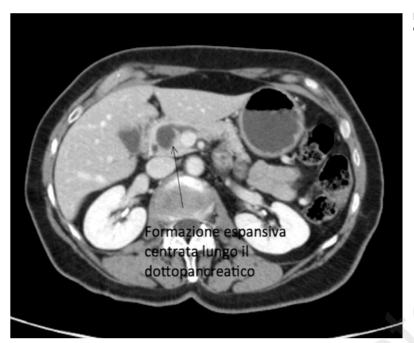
CT scan image shows an expansive cystic lesion along the pancreatic duct.
